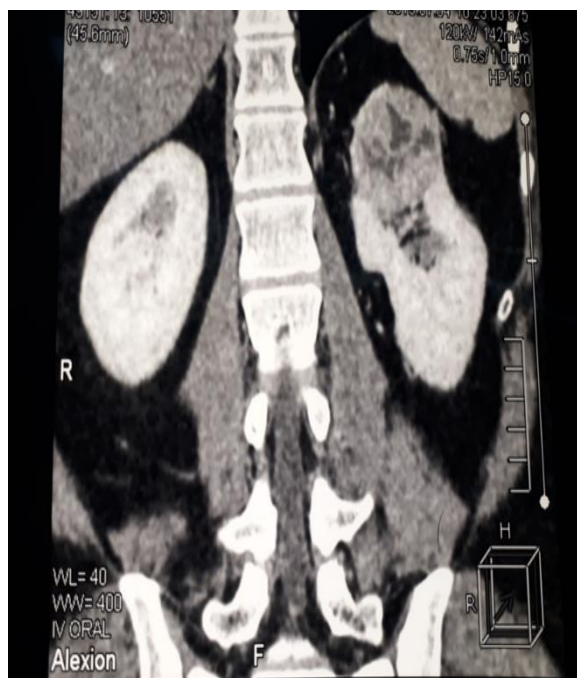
CT Urogram image of the tumor in the upper pole of left kidney
